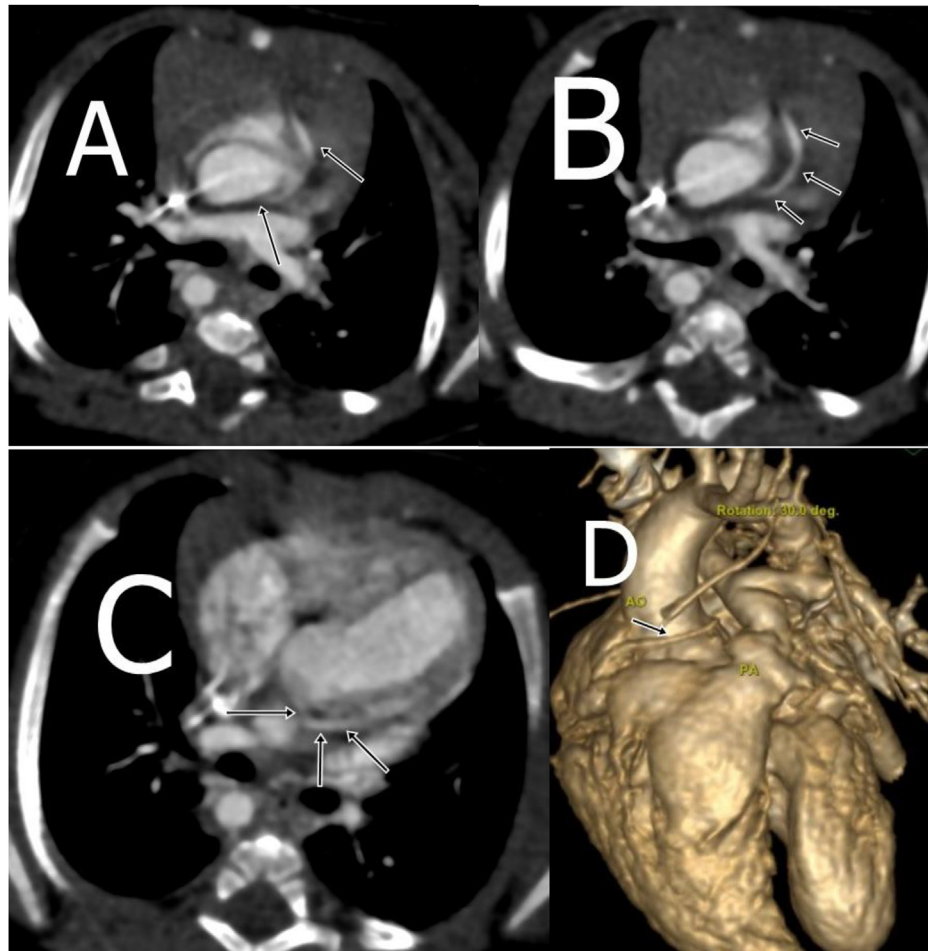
Anomalous origin of right coronary artery from left coronary sinus on computed tomography angiography. (A) Axial computed tomography angiography image showing origin of right coronary artery (arrow) arising from the left coronary sinus. (B) Axial oblique computed tomography angiography showing right coronary artery (black arrows) with pre-aortic course. (C) Axial computed tomography angiography image showing normal origin of left coronary artery. (D) VR image showing anomalous origin of right coronary artery with pre-aortic course (arrow).
